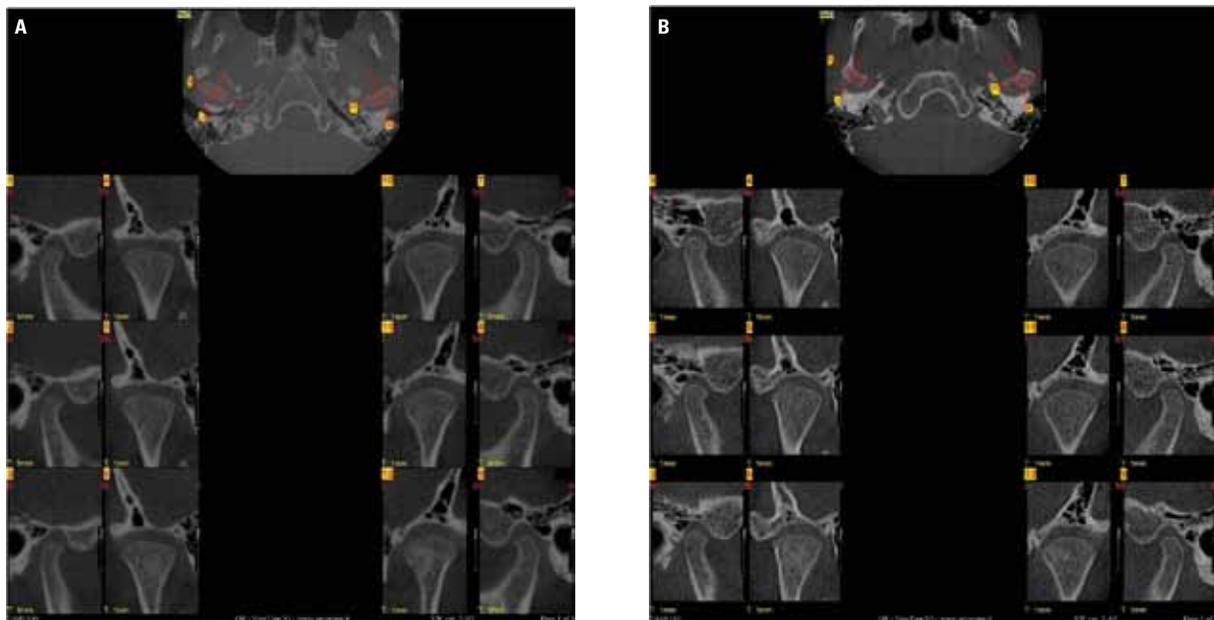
A) Initial CT scan of TMJ regions. B) Final CT scan of TMJ regions.
